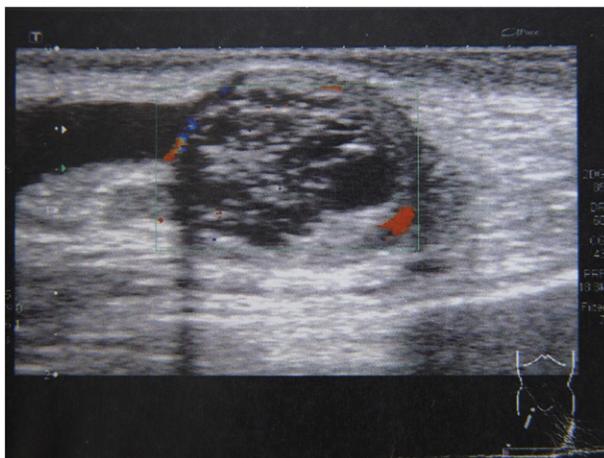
Scrotal ultrasound scan revealing a $2.6 \times 1.6 \times 1.4$ -cm hyperechoic multilocular cystic mass of the right testis.
